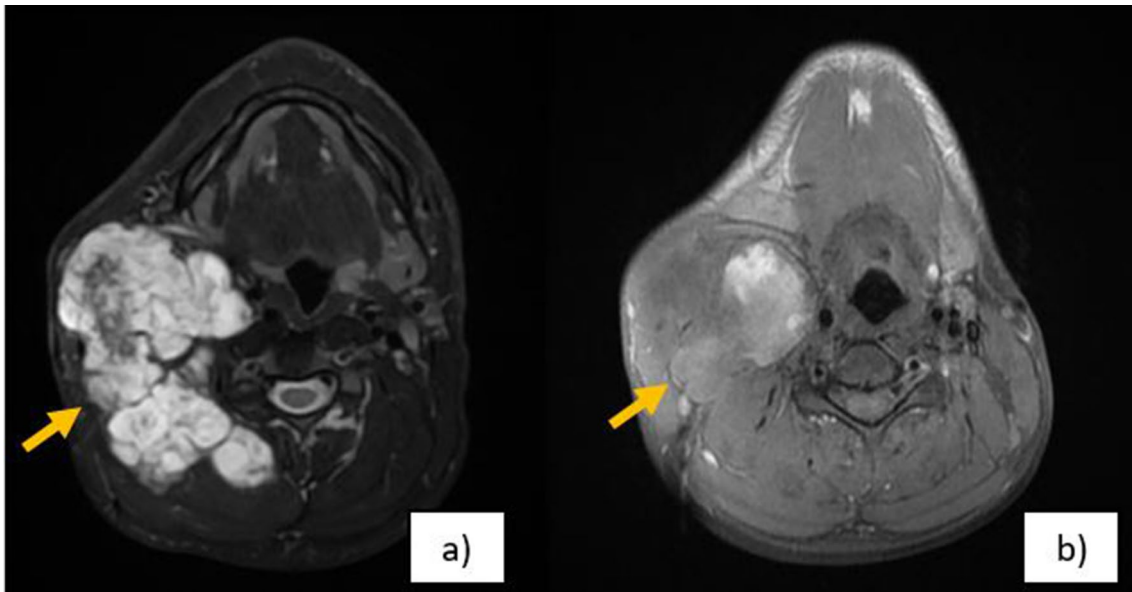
a MRI coronal with contrast. b MRI coronal plain. Images showing a right parotid mass involving the Paraspinal muscles, extending to parapharyngeal space
